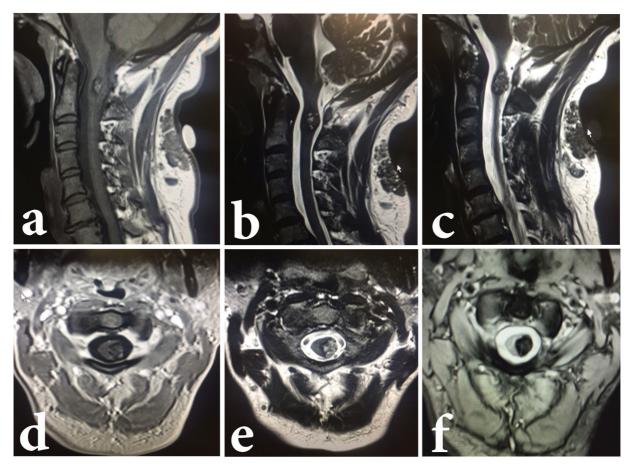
(a) Sagittal T1-weighted magnetic resonance imaging (MRI) of the cervical spine, evidencing a hyperintense lesion, with a hypointense halo at the C1-C2 level. (b, c) Sagittal T2-weighted MRI of the cervical spine, evidencing the typical blueberry aspect of cavernomas, with a mixture of hyperintense and hypointense signals at the C1-C2 level. (d) Axial T1-weighted MRI of the cervical spine, showing the right lateral aspect of the lesion in relation to the cervical spine. (e) Axial T2-weighted MRI of the cervical spine, highlighting the cleavage plane between the lesion and the cervical spine, and the irregular signal. (f) Axial T2*-weighted MRI of the cervical spine, evidencing the vascular pattern (hyposignal) of the lesion.
